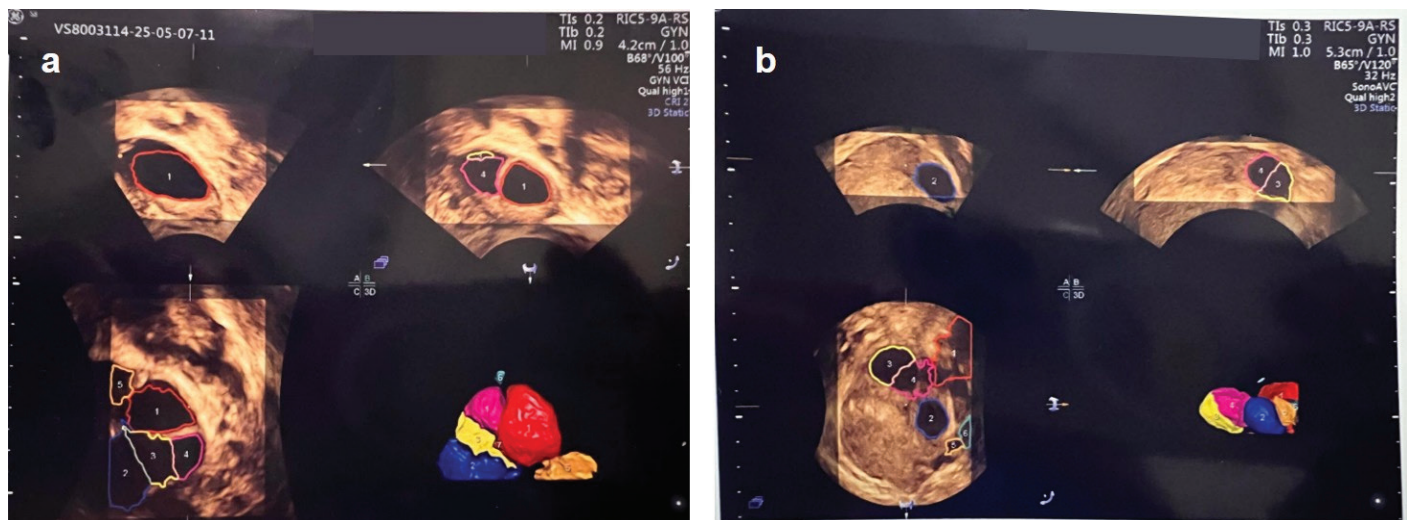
Examples of semi-automatic measurement of follicle volumes using three-dimensional ultrasound and SonoAVC software. Each follicle is marked with a different color and numbered. (a) Number “2” was incorrectly identified as a follicle by the software and required manual correction as it was a blood vessel section. (b) Number “1” is an example of free fluid around the ovary being detected as a follicle by the software
